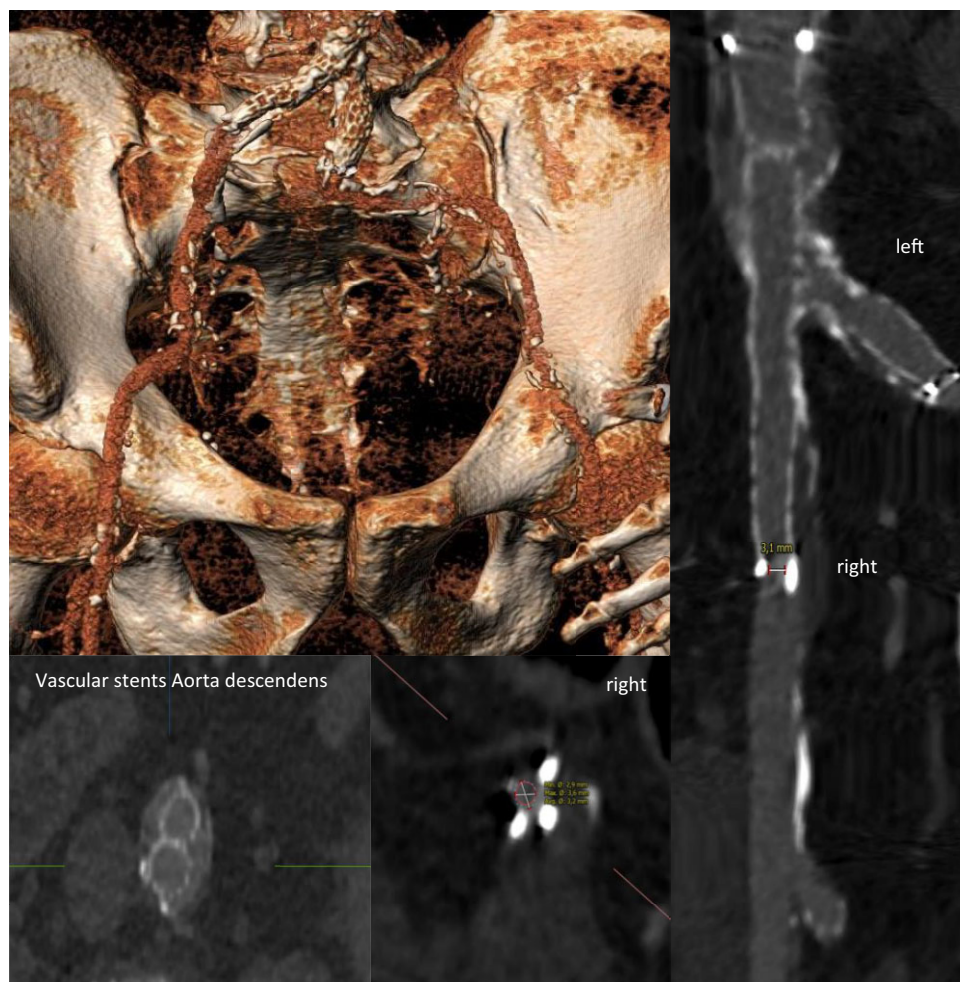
Computed tomography scan of ilio-femoral axes showing existing stents (undersized) and bilateral calcified stenosis.
